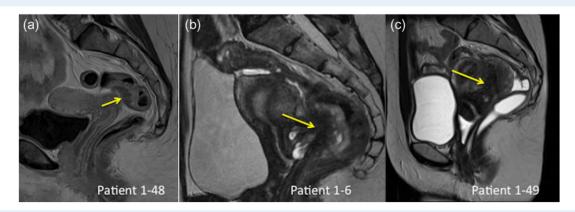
Preoperative MRI assessment in patients managed by shaving (a), disc excision (b) and segmental resection (c).
